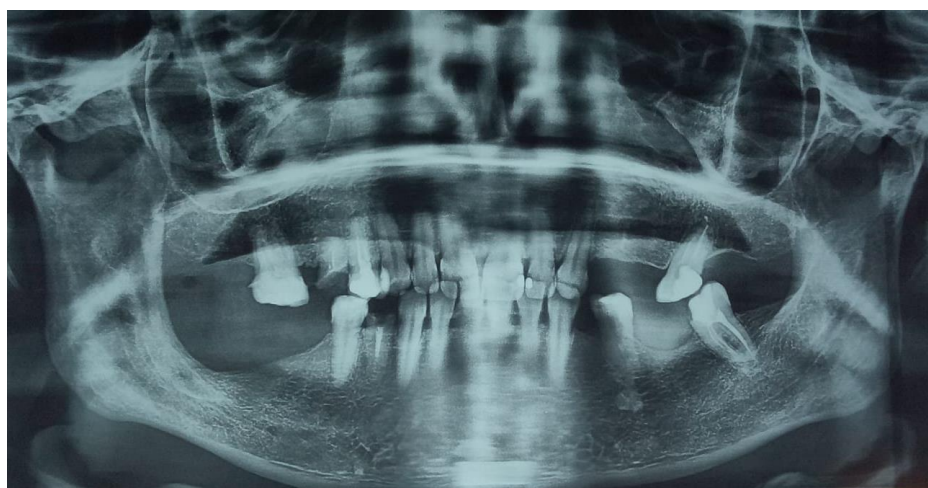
18 months postoperative panoramic radiograph.
